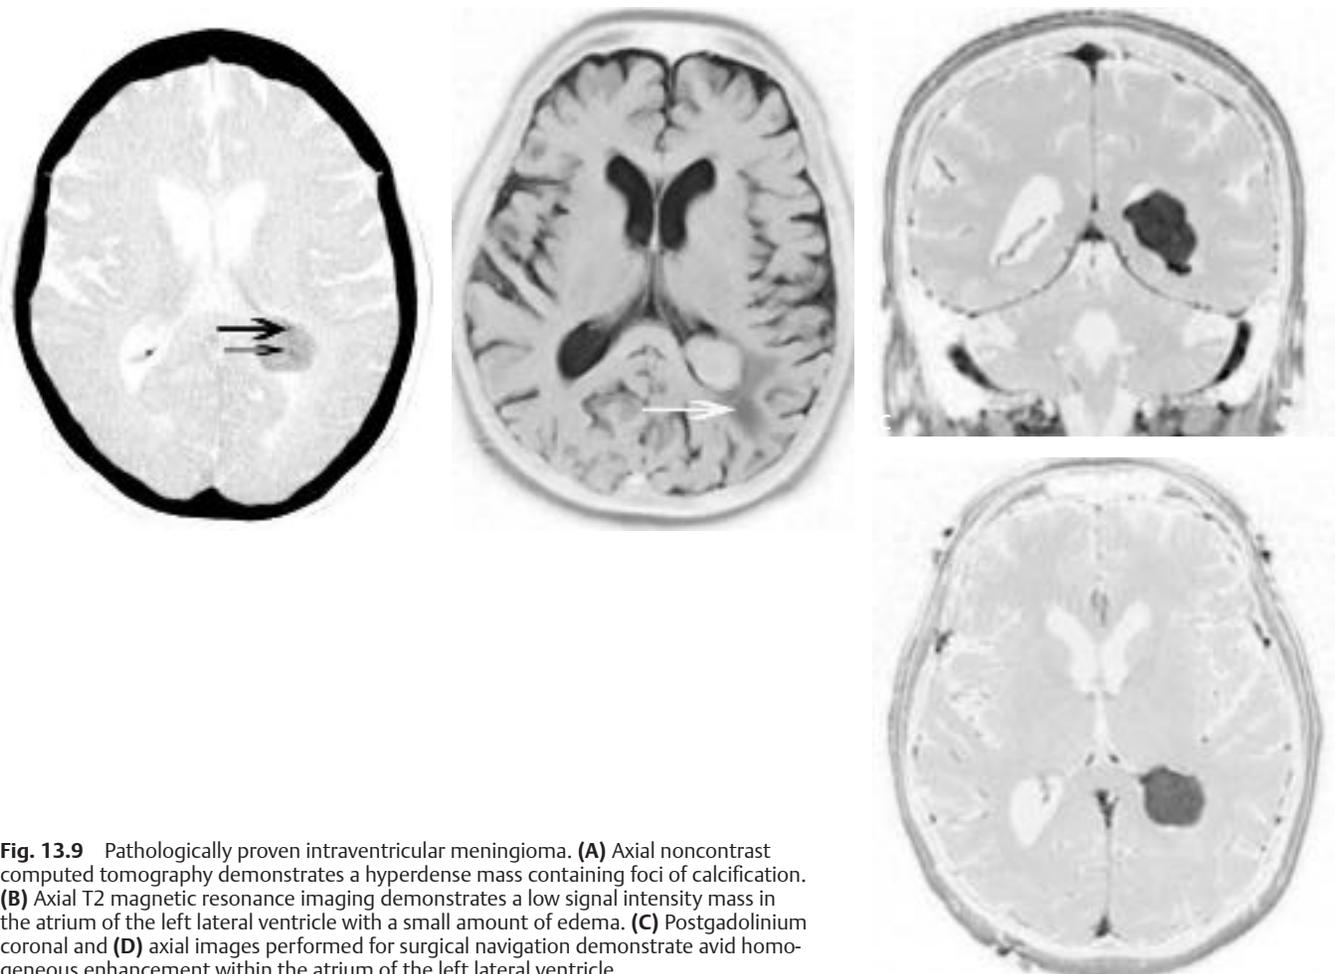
Pathologically proven intraventricular meningioma. (A) Axial noncontrast computed tomography demonstrates a hyperdense mass containing foci of calcification. (B) Axial T2 magnetic resonance imaging demonstrates a low signal intensity mass in the atrium of the left lateral ventricle with a small amount of edema. (C) Postgadolinium coronal and (D) axial images performed for surgical navigation demonstrate avid homogeneous enhancement within the atrium of the left lateral ventricle.
